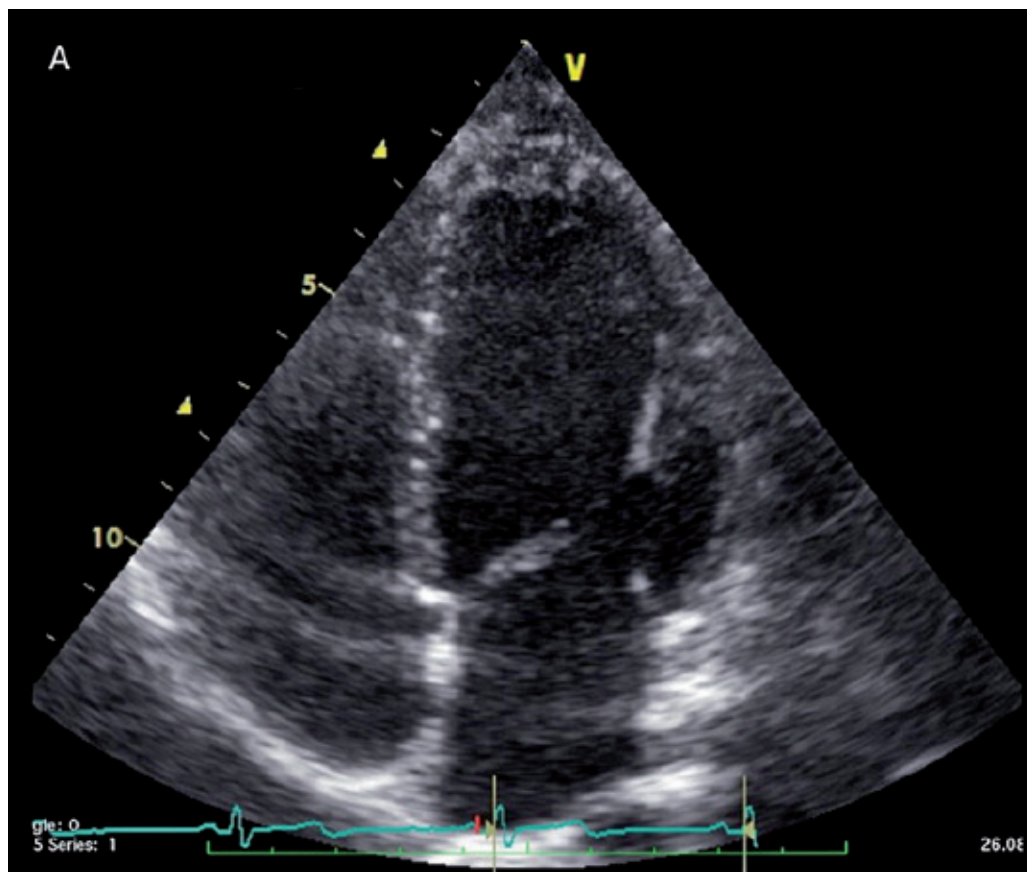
Transthoracic echocardiography (4-chamber view) of a child with a confirmed diagnosis of tuberous sclerosis. Regression of rhabdomyomas after 4 years of follow-up
